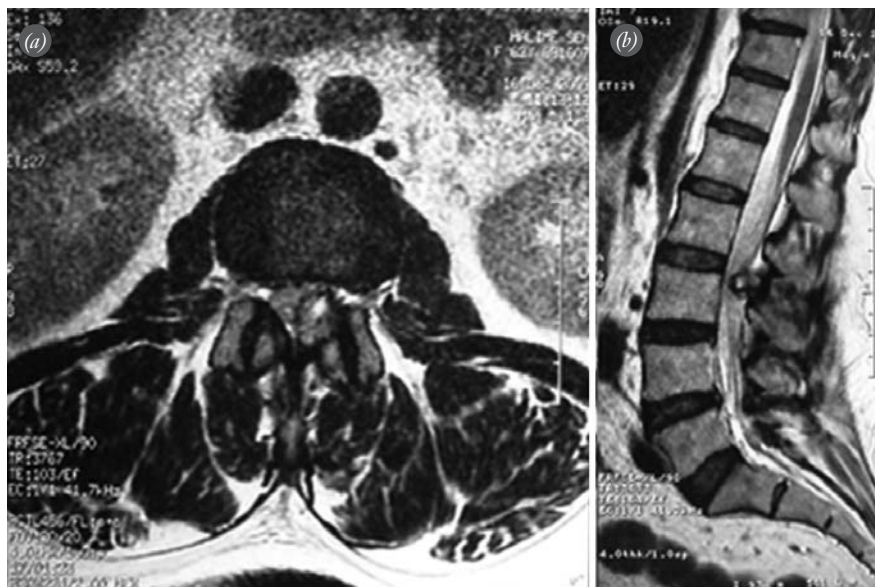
(a) Axial and (b) sagittal T1-weighted MRI revealed the central high-intensity core of the tumor surrounded by a ring-like low-intensity area and the marked stenosis of the spinal canal with compression of the caudal nerve roots.
